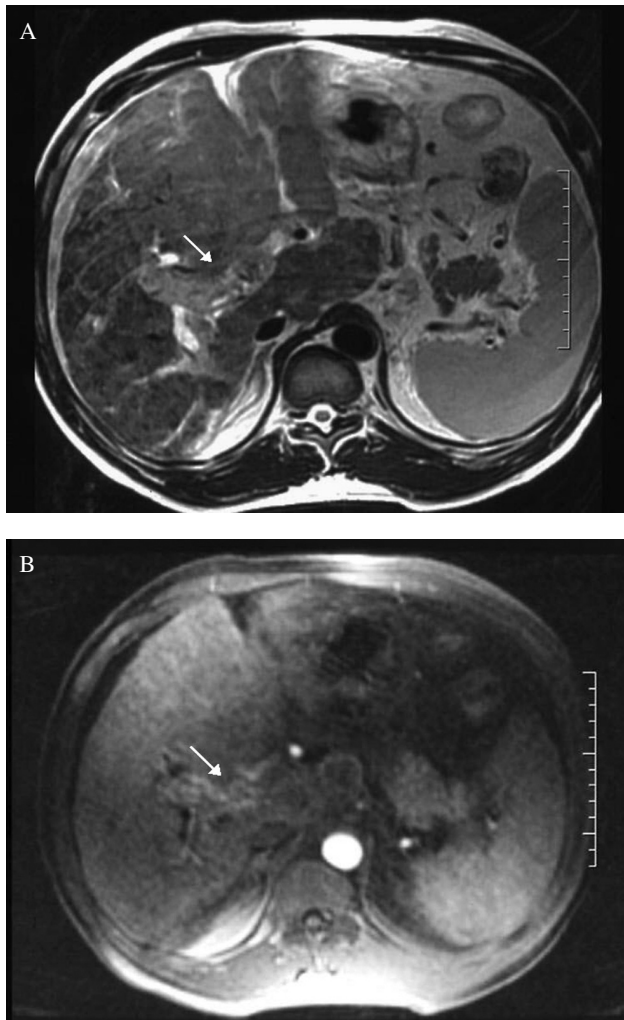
A 45-year-old male with a large HCC and with serum alpha-fetoprotein level of 106 ng/ml. On T2-weighted axial MR image (A), there is an expansile hyperintense tumor thrombus within the right portal vein (arrow). Contrast-enhanced arterial-phase axial MR image (B) demonstrates the enhancement in the thrombus supporting the diagnosis of malignant PVT (arrow).
